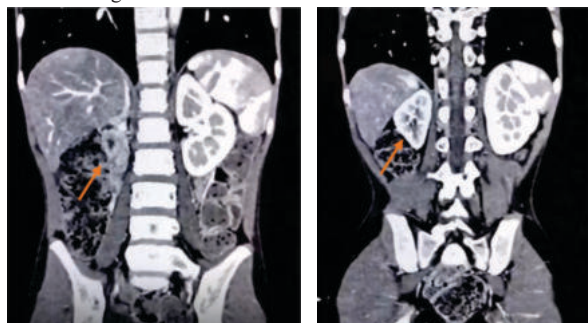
CT- Abdomen and Pelvis Shows Contracted Right Kidney (Red Arrow).
